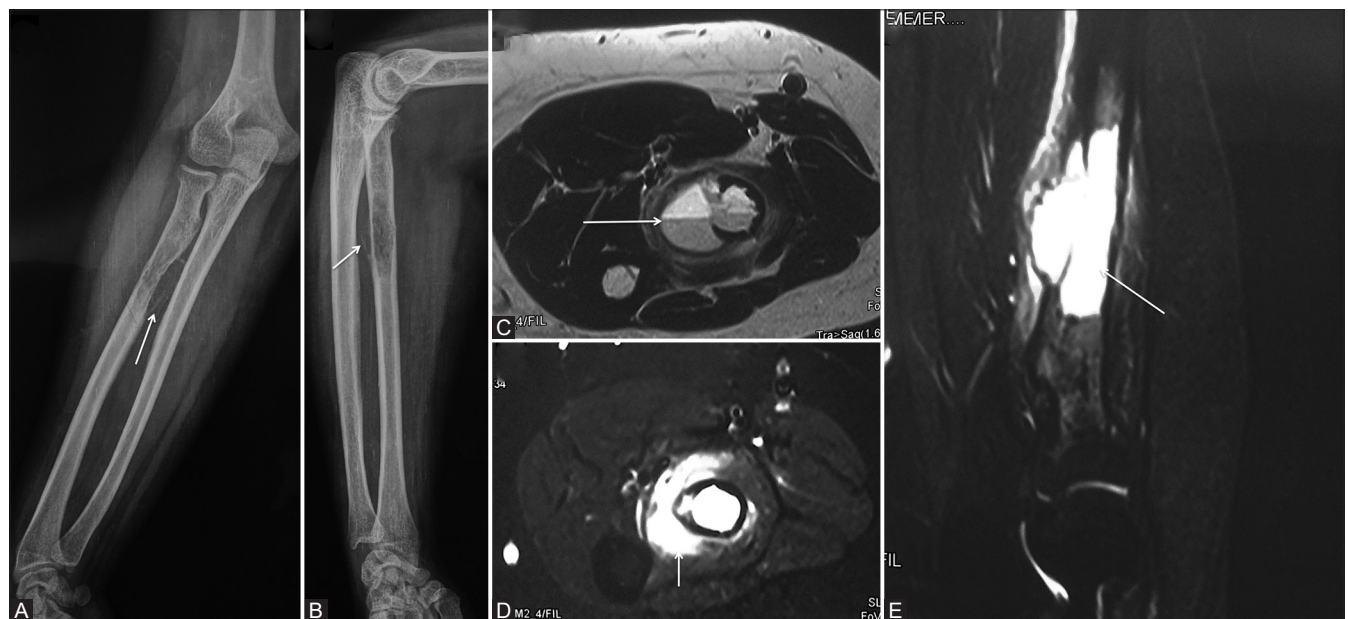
(A-E): A 16-year-old young female with swelling in the right forearm. (A and B) AP and lateral radiographs of the forearm showing expansile, eccentric cortical based lytic lesion with a thin-shelled cortex arising from the proximal diaphysis of radius (arrow, A and B). (C-E) Axial T2W, Axial T2W fat-saturated and Sagittal T2W fat-saturated MR images showing large exophytic soft tissue component with blood-fluid levels (arrow, C) with extensive soft tissue (arrow, D) and marrow oedema (arrow, E)
